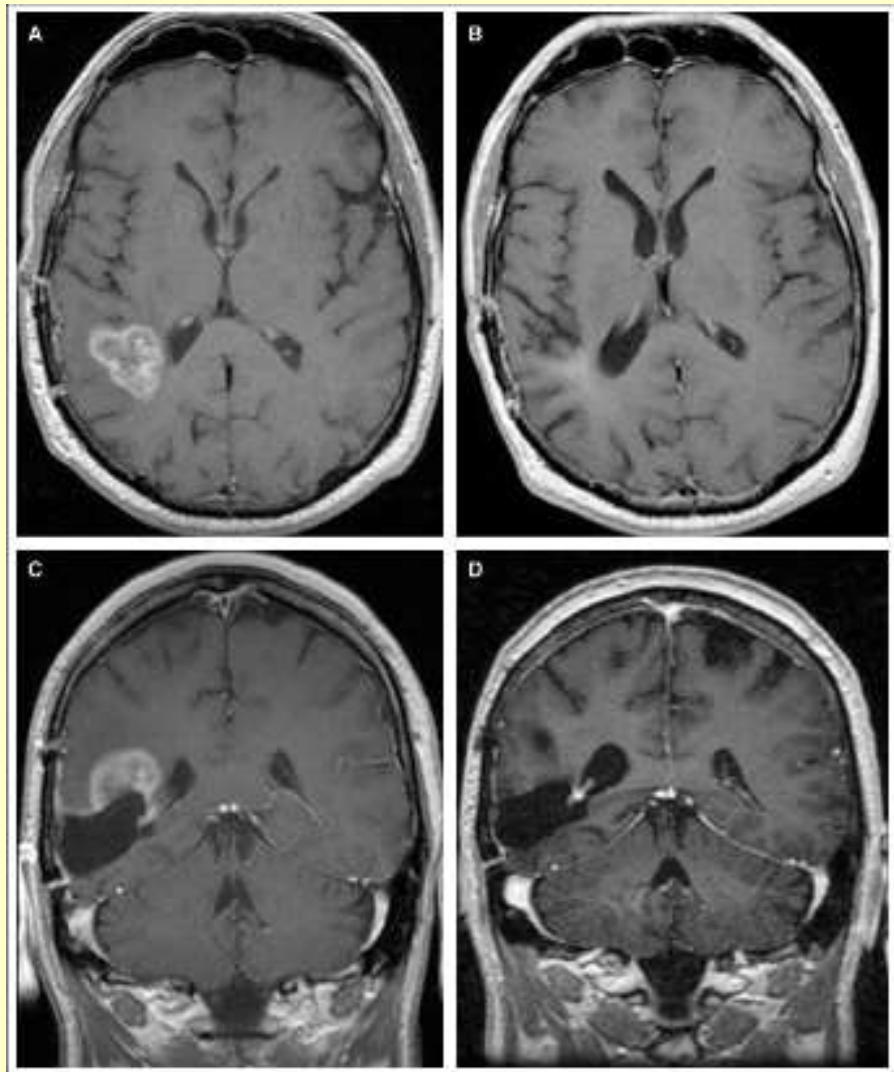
Baseline and post-treatment magnetic resonance imaging of a patient treated with temozolomide and radiation. Post-treatment axial and coronal T1-weighted magnetic resonance scans are shown with glioblastoma multiforme in A, B, baseline and C, D, after four cycles of temozolomide treatment.
